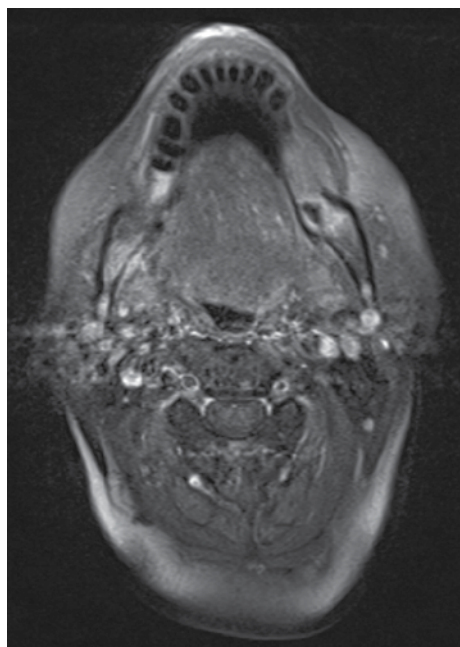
MRI scan of the head and neck.
